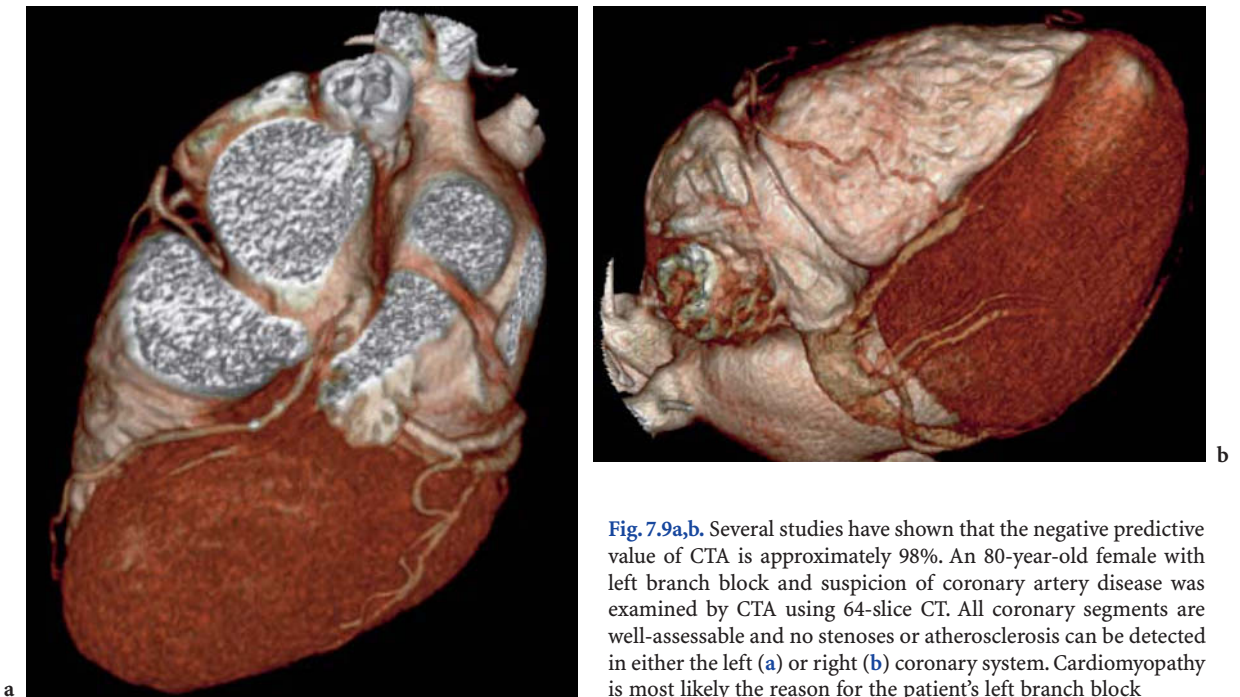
Several studies have shown that the negative predictive value of CTA is approximately 98%. An 80-year-old female with left branch block and suspicion of coronary artery disease was examined by CTA using 64-slice CT. All coronary segments are well-assessable and no stenoses or atherosclerosis can be detected in either the left (a) or right (b) coronary system. Cardiomyopathy is most likely the reason for the patient's left branch block
